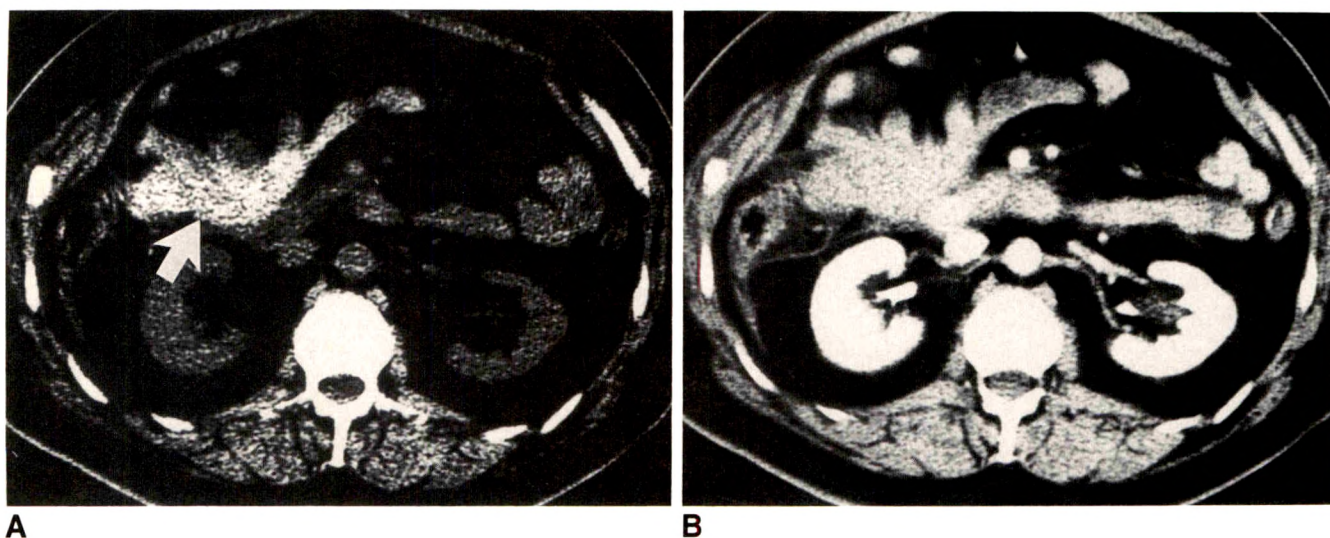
A and B, CT scans. Mesenteric hematoma (arrow) on a nonenhanced scan (A) was mistaken for nonopacified bowel on a contrast-enhanced scan (B).
